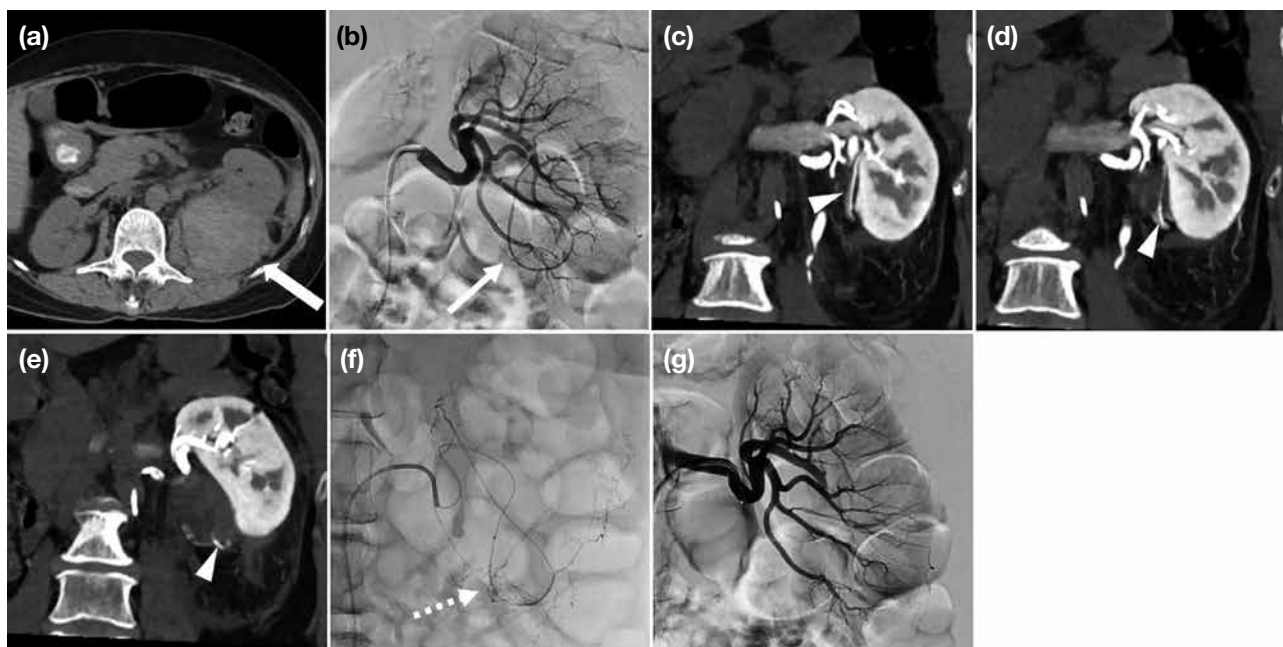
(a) A 70-year-old patient. Pre-contrast computed tomography (CT) of the kidneys shows a left renal lower pole mass with internal hyperdensities (arrow), suggesting intratumoural haemorrhage. Arterial phase CT shows no pseudoaneurysm or active contrast extravasation. (b) The left main renal artery was cannulated with a catheter (5-Fr C1 catheter; Cordis, Miami Lakes [FL], US) and digital subtraction angiography (DSA) performed, showing a long curved tortuous inferior segmental artery to the left lower pole (arrow), with dysplastic distal branches. (c-e) With angiography-computed tomography, this was confirmed to be the feeding artery (arrowheads) to the haemorrhagic renal lesion, without pseudoaneurysm or active contrast extravasation. (f) The feeder was selectively cannulated with a 2.4-Fr microcatheter (Maestro; Merit Medical Systems, Warrington [PA], US) with DSA confirming its supply to the renal lesion (dashed arrow). Embolisation was performed with Embospheres 500-700 μ m (Merit, Warrington [PA], US) until stasis was achieved. (g) Check of left renal angiogram showing successful occlusion of the bleeding artery.
